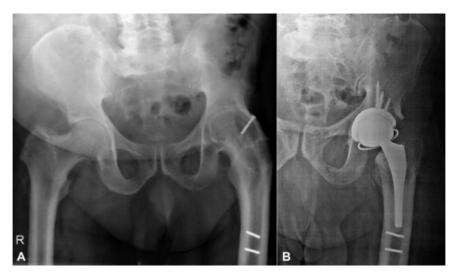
(A) radiography showing left hip arthrodesis; (B), radiography showing left hip desarthrodesis at 4 years of postoperative follow-up.
